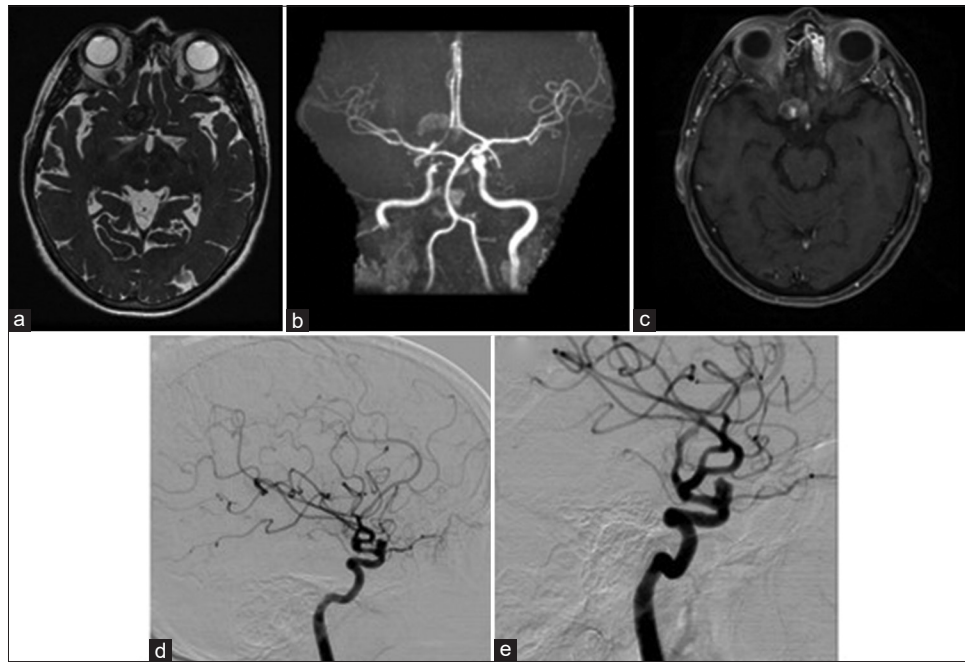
First postprocedure follow-up imaging. (a) Magnetic resonance imaging (MRI) in the T2 sequence showing aneurysmal thrombosis. (b) MRI angiogram showing persistence of intra-aneurysmal blood flow. (c) T1 sequence with contrast showing a small amount of intra-aneurysmal blood flow. (d and e) digital subtraction angiography (DSA) control 6 months after flow-diverter placement showing reduction of aneurysm size with persistence blood flow in the aneurysm's neck
